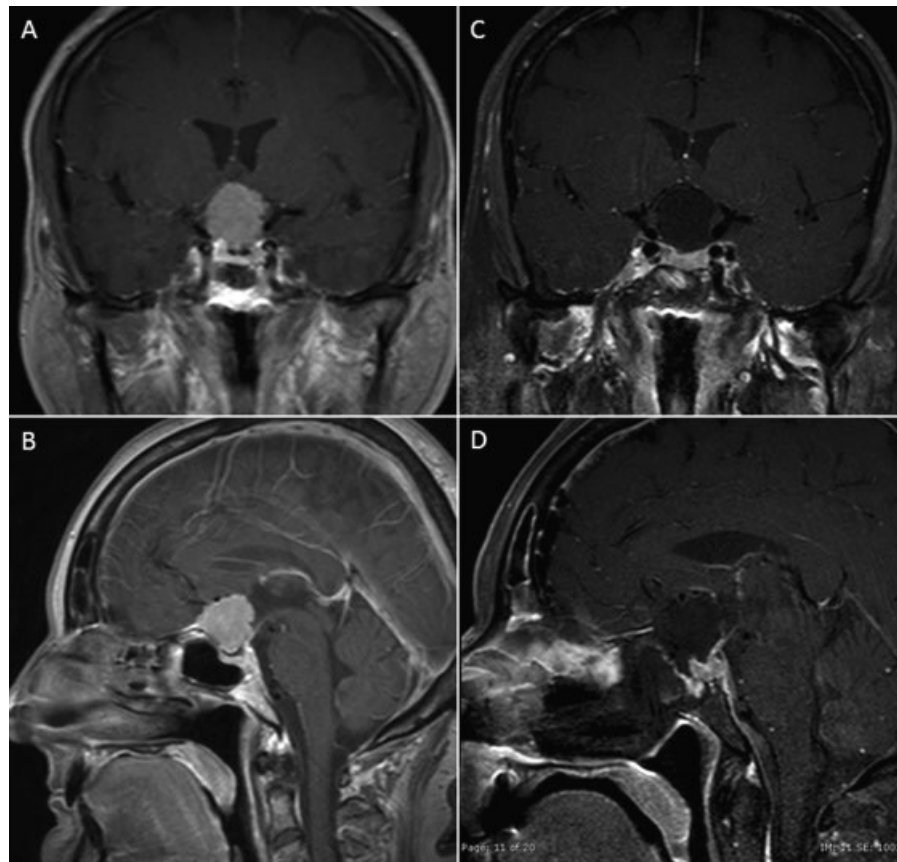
Case 2. (A, B) Preoperative T1-weighted images with gadolinium demonstrating a homogeneously enhancing lesion arising from the tuberculum sellae causing significant elevation of the optic chiasm. (C, D) Initial postoperative images demonstrate a gross total resection with no evidence of residual.
